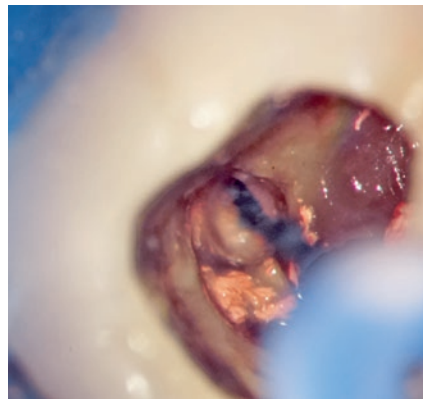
Lateral cleaning of the canals using an anatomical file (here the XP Shaper file was used [FKG Dentaire, LaChauxdeFonds, Switzerland]) and/or ultrasonic tips. The Dual Rinse HEDP gives a mild decalcifying effect to the NaOCl solution used for this purpose. This makes it easier to remove filling materials from the dentin wall; thus, solvents such as chloroform, which are not permitted for this purpose can be avoided.
